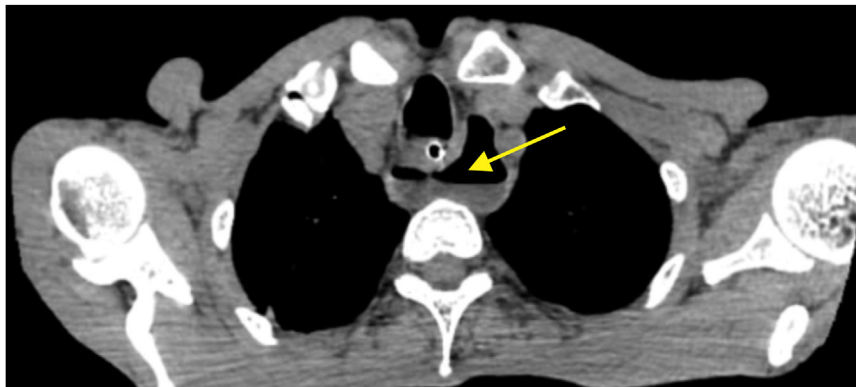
Noncontrast CT scan of the neck shows large Zenker's diverticulum (*yellow arrow*) arising from the midline of posterior wall of distal pharynx.
